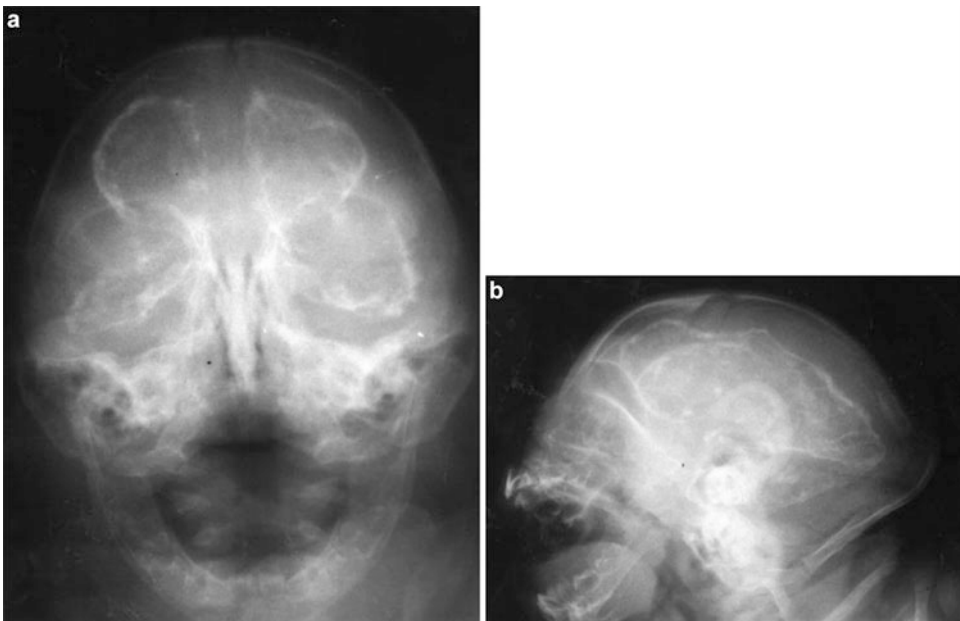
(a, b) Skull radiographs of another patient with congenital CMV infection showing microcephaly and typical intracranial ventricular subependymal calcifications
